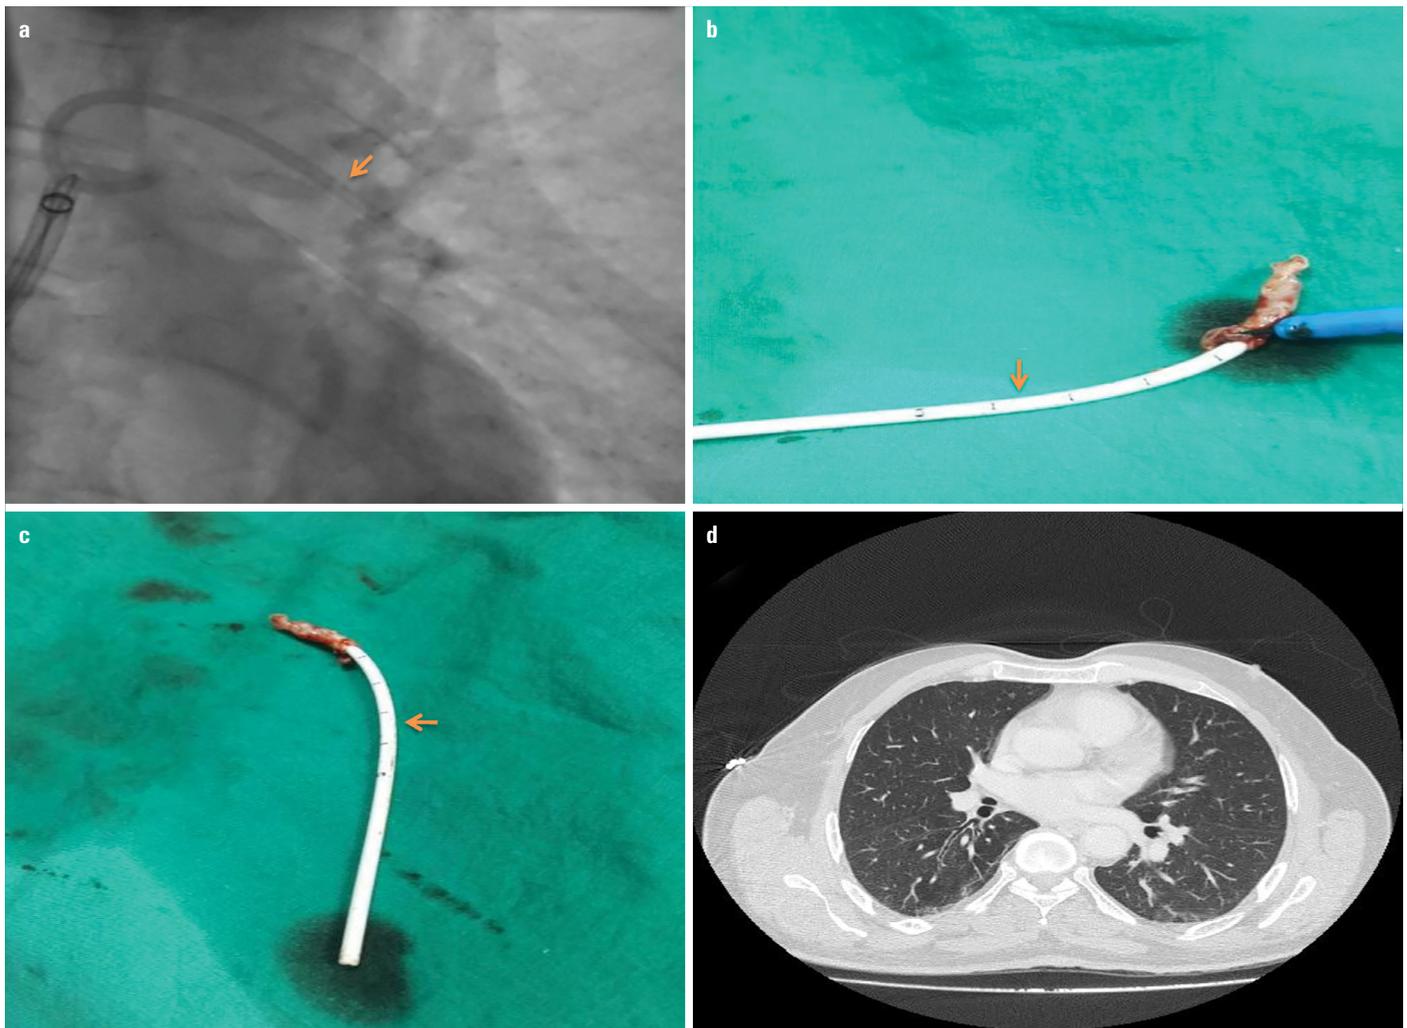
The embolized Port-A-Cath (yellow arrow) is entrapped between the snare and the distal portion of the 14-French ablation catheter (a). Macroscopic images of the embolized Port-A-cath (yellow arrow) (b, c). Thorax computed tomography shows that there is no acute pulmonary pathology (d)
